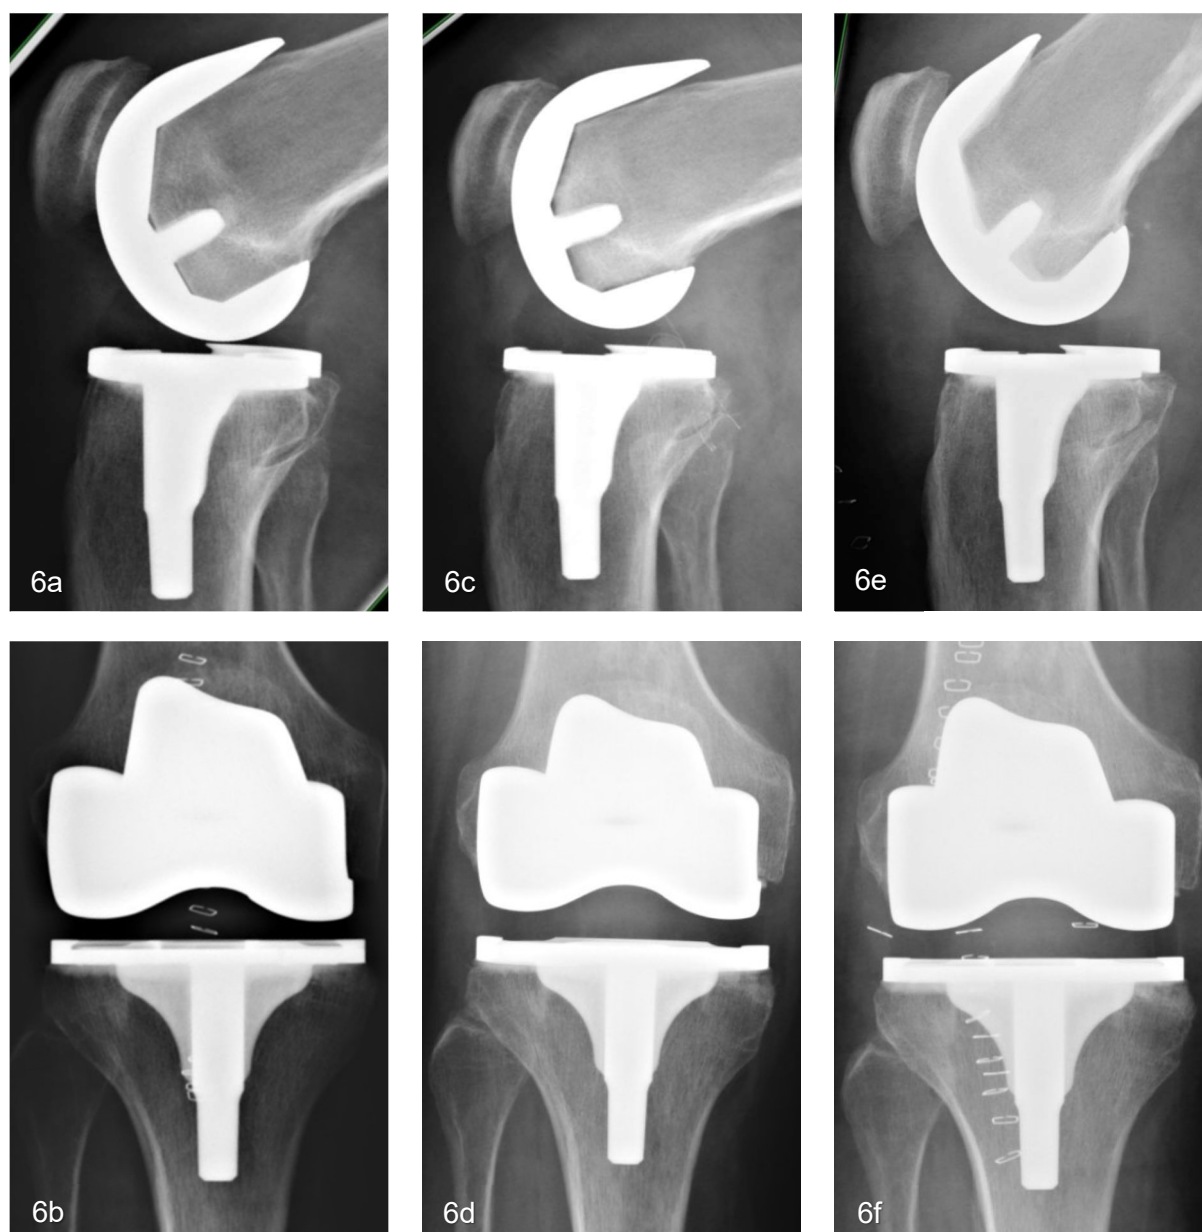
a-f – Radiography in two planes of a total knee arthroplasty of the right side in a 57-year-old female patient. a+b: Directly after primary implantation. c+d: 12 weeks follow-up – initial loosening of the femoral component. *Staphylococcus epidermidis* was identified in a single sample of a performed biopsy. e+f: After one-stage exchange of mobile parts and exchange of the femoral component implanted with antibiotic loaded cement combined with 8 weeks dual antibiotics.
